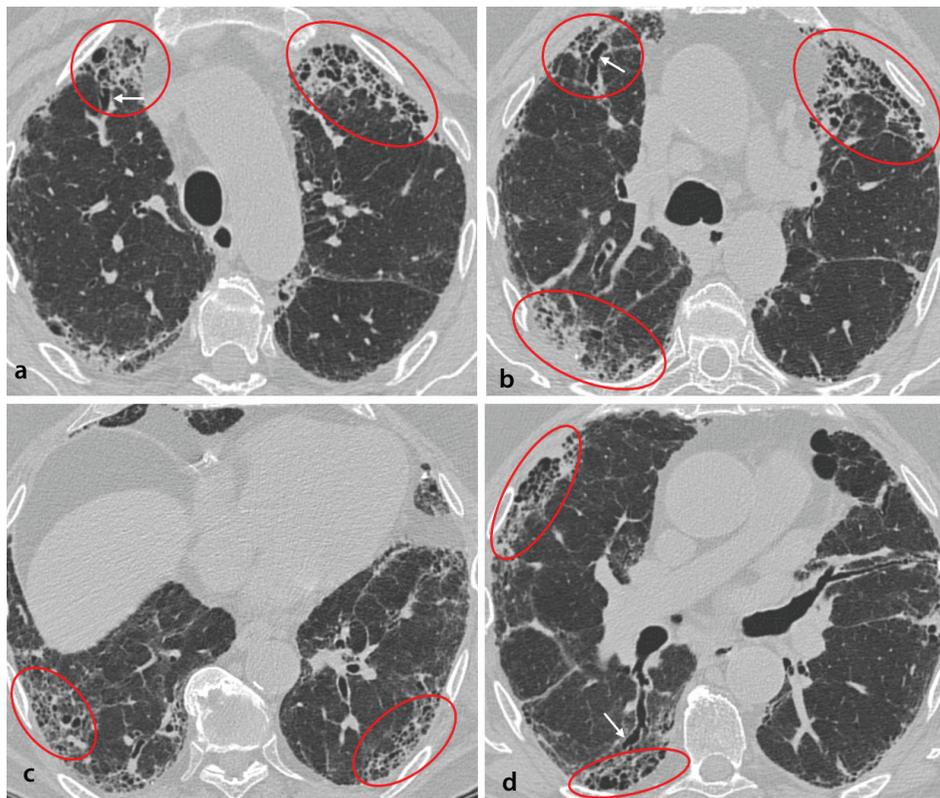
Usual interstitial pneumonia pattern on chest computed tomography (CT). Axial CT images (a–d) demonstrate characteristic UIP features, including basal and subpleural reticulation, honeycombing (red circles), and traction bronchiectasis (arrows). Fibrotic changes are heterogeneously distributed with basal and subpleural predominance and relative sparing of the central regions in a patient with idiopathic pulmonary fibrosis. UIP, usual interstitial pneumonia.
